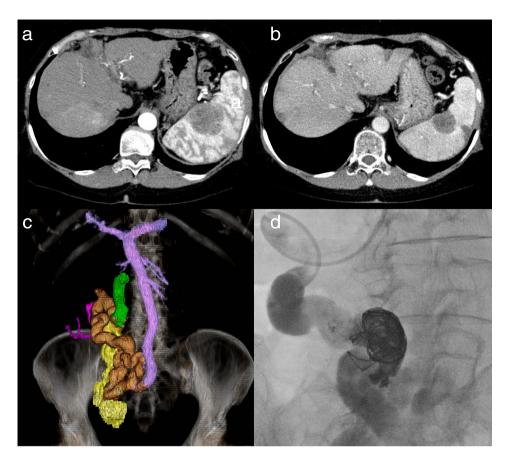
(a) Abdominal contrast-enhanced computed tomography (CT) before lenvatinib administration. Multiple metastases mainly metastasized around the spleen. (b) Abdominal contrast-enhanced CT 24 weeks after lenvatinib administration. Multiple metastases are smaller in size. (c) Reconstructed image of portosystemic shunt. Green indicates the ovarian vein, purple indicates the superior mesenteric vein, and orange indicates the shunt. (d) Angiographic image during shunt embolization.
